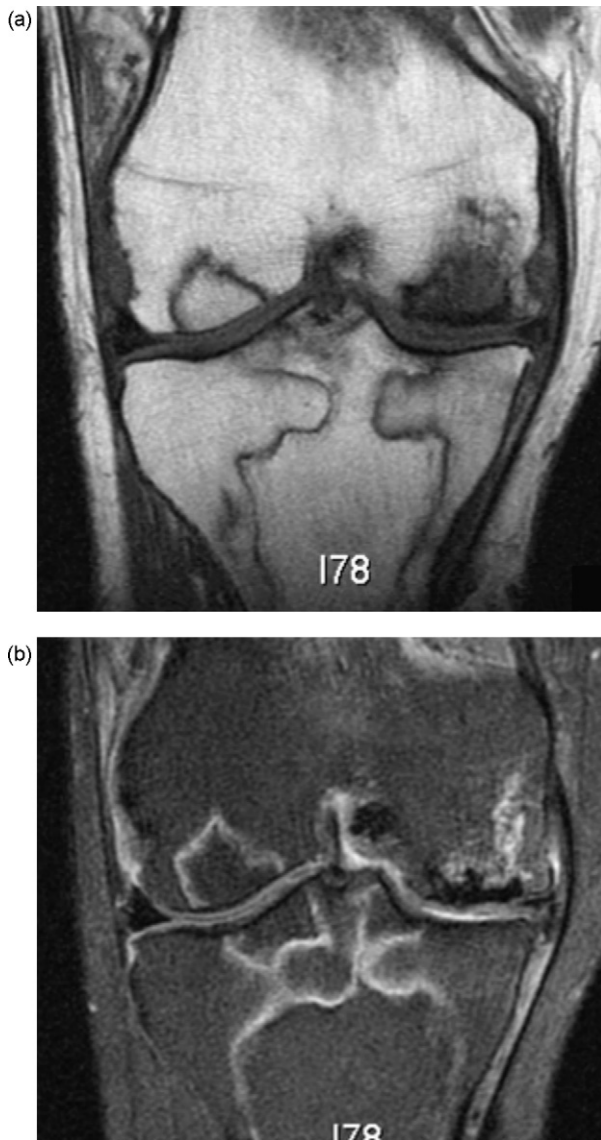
59-year-old female with asthma and HIV infection. MRI of the knee obtained for knee pain. (a and b) Coronal T1 and T2-weighted images show the typical irregular contoured, well demarcated lesions within the marrow and subchondral bone, representing areas of necrosis. Note the dark signal margin between the normal and abnormal bone (arrows). The area of necrosis in the medial femoral condyle is fairly large.
